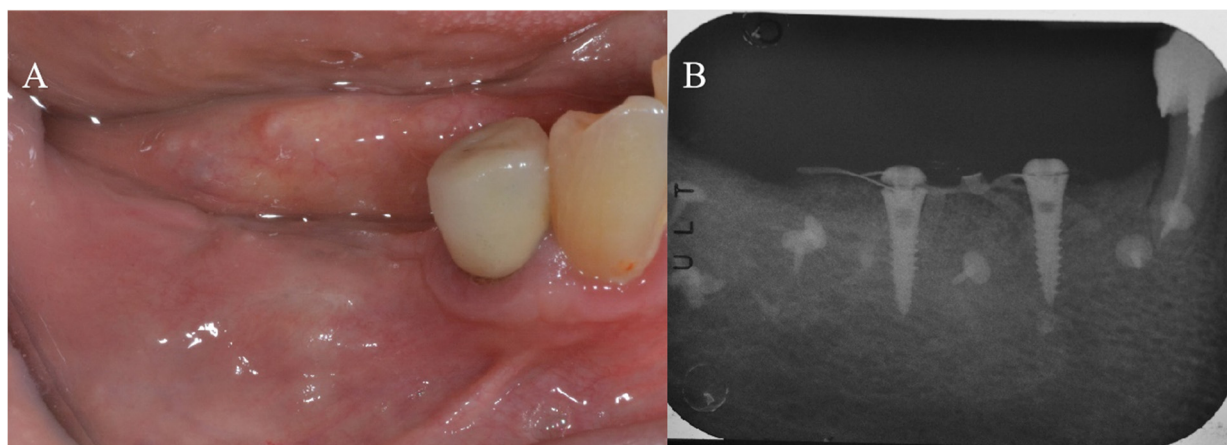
The yet thin band of keratinized mucosa was reduced (A), due to the coronal movement of the flaps, and the follow-up radiograph showed a still immature bone (B).
